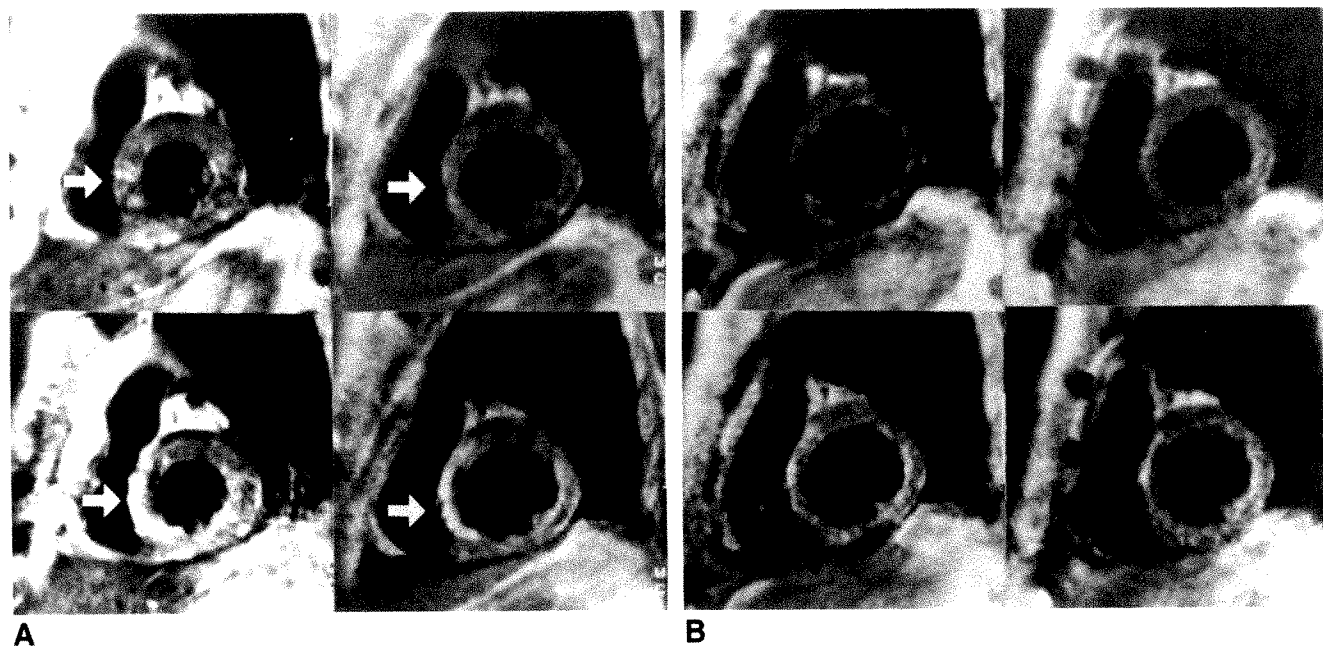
Serial assessment of acute anteroseptal myocardial infarction (arrows) by using gated MR imaging with Gd-DTPA. Pulse sequences were SE 800/35, SE 800/35, SE 820/35, and SE 820/35 at 5, 12, 30, and 90 days, respectively.
